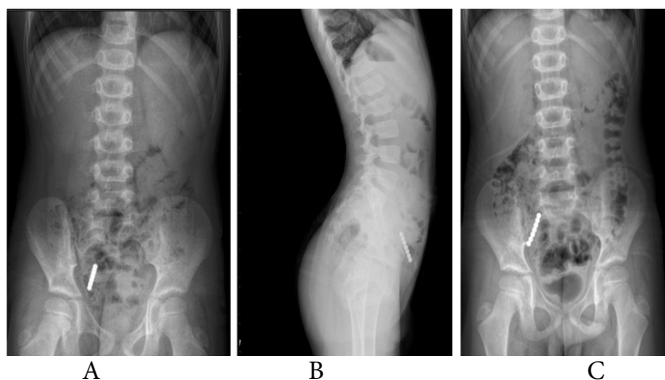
A-B. Abdominal A-P (A) and lateral (B) X-ray taken of the patient in a standing position at the time of admission to our clinic (7 days after swallowing). Demonstrating seven clustered spherical radiopaque magnets persistently localized in the right lower quadrant. C. Preoperative abdominal X-ray taken (30 days after swallowing). No change in the position of the contrast medium was observed.
